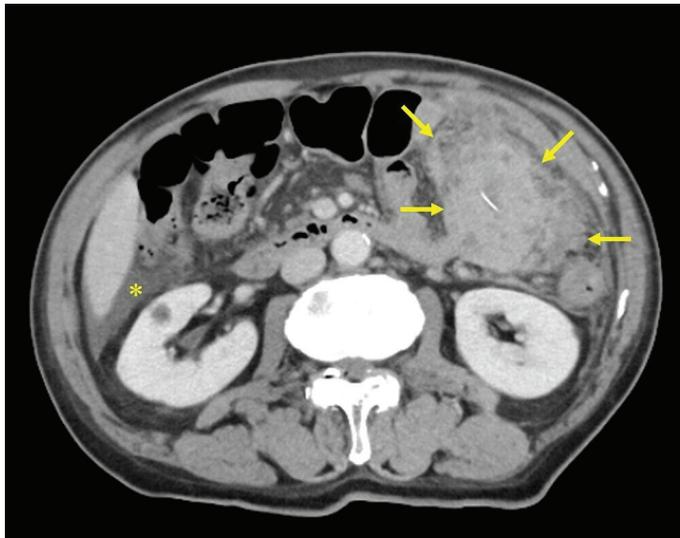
Contrast-enhanced computed tomography image showing a small amount of ascites (asterisk) and an 84 x 66 mm mass containing a linear opacity in the left upper abdominal cavity (arrow).
